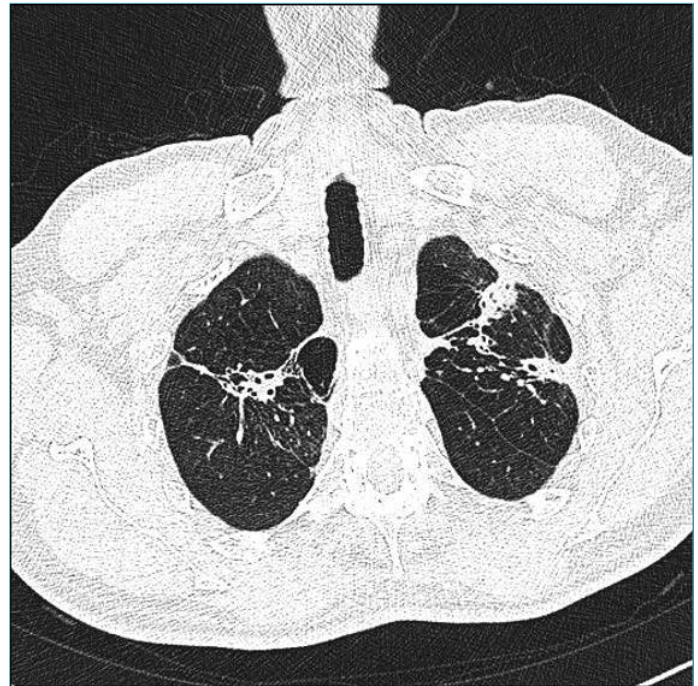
Control thoracic CT
